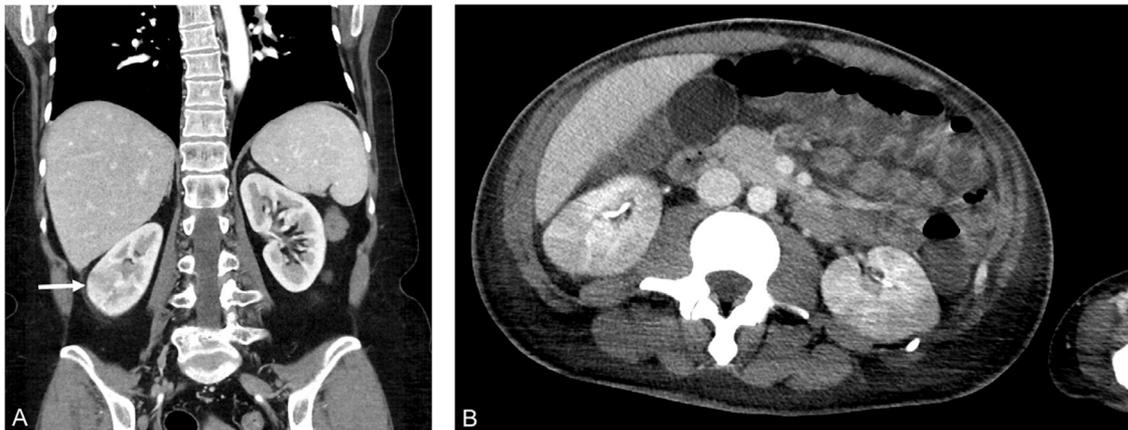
Pyelonephritis on contrast-enhanced CT. (A) A 48-year-old woman with right-sided abdominal pain and an abnormal urinalysis. Focal pyelonephritis in the right kidney (white arrow) was missed; diagnosis is more difficult because of the corticomedullary phase of imaging and the focal nature of the finding. (B) A 57-year-old man with fever and T-cell lymphoma. Bilateral striated nephrograms in the nephrographic phase were missed; this case of pyelonephritis is difficult to appreciate due to streak artifact from a lowered left arm.
